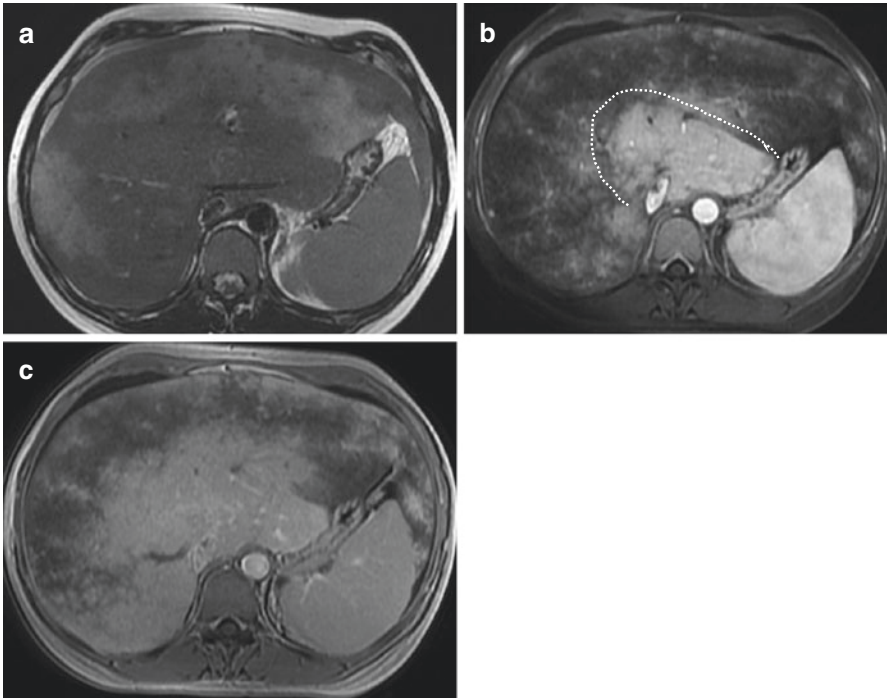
Budd–Chiari syndrome in a 43-year-old female with myeloproliferative neoplasm. MRI shows zonal perfusion visible as signal hyperintensity of peripheral liver parenchyma due to congestion on T2-weighted images (a), heterogeneous signal with a “mosaic enhancement pattern” while the caudate lobe shows preserved enhancement on contrast-enhanced arterial (b) and portal venous phase images (c)
